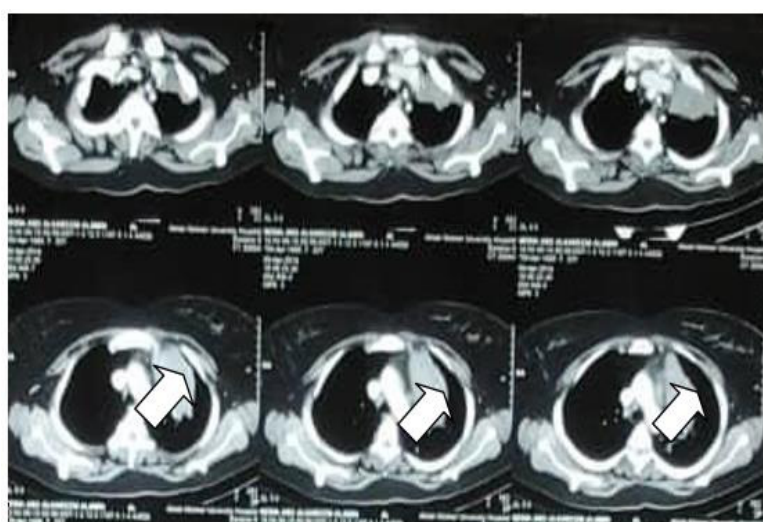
CT chest with contrast
